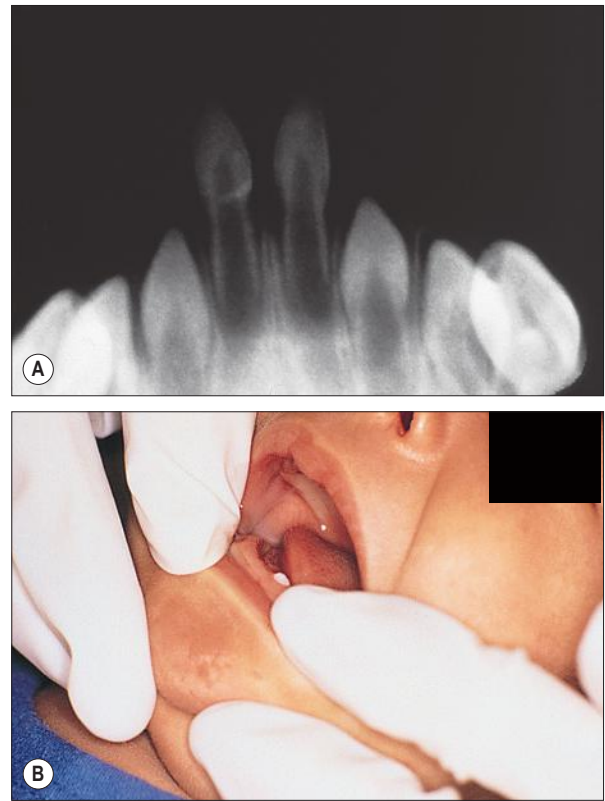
(A) Radiograph of natal teeth. (B) Natal teeth on the lower alveolar ridge of an infant.
